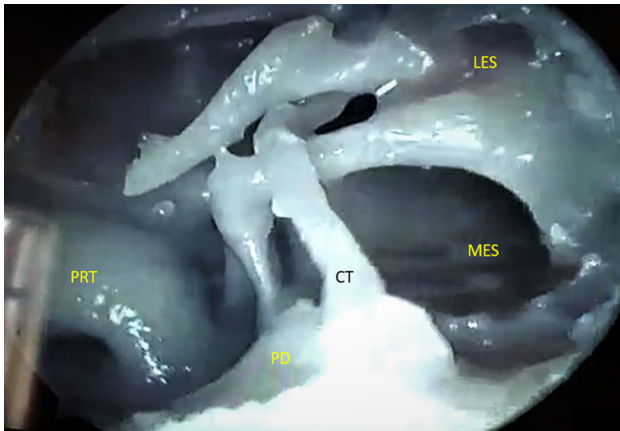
Demonstration of the ossicles along with chorda tympani nerve (CT), Lateral epitympanic space (LES), Medial epitympanic space (MES), Pyramid (PD), Promontory (PRT)
